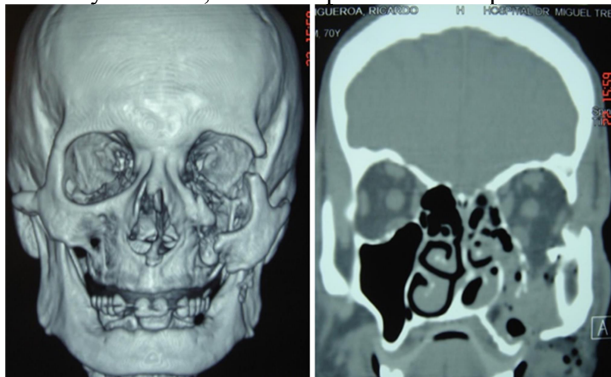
CT with bone reconstruction showing multiple fractures involving the upper jaw, zygomatic bone and floor of the orbit.
